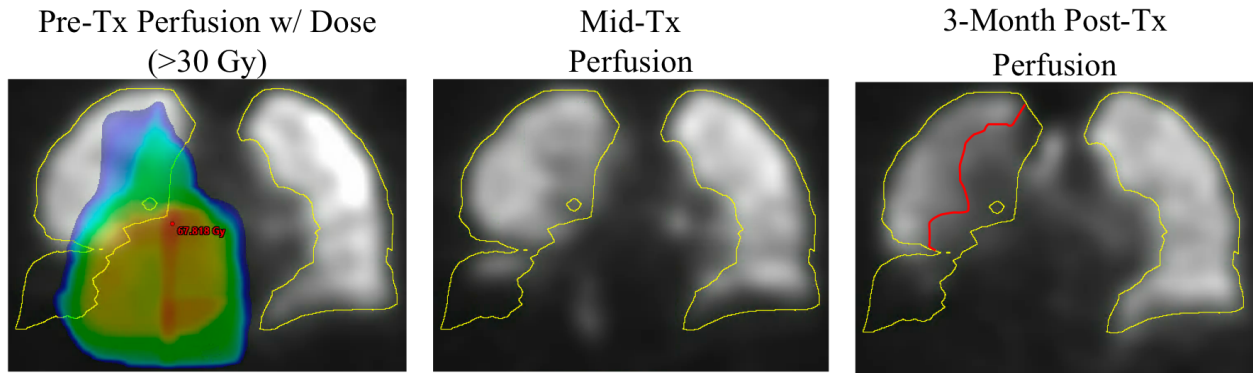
A qualitative example of the perfusion SPECT scans for patient UM025 demonstrating the dose-function response during and after radiation treatment. Planned dose >30 Gy is overlaid on the pre-treatment perfusion scan and the red contour is included to show areas of observed perfusion reduction.
